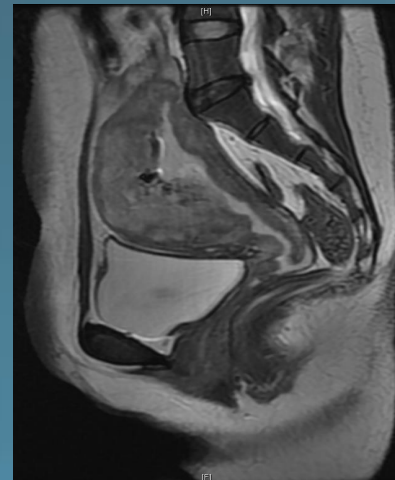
MRI Pelvis 5 days post hysteroscopic resection
